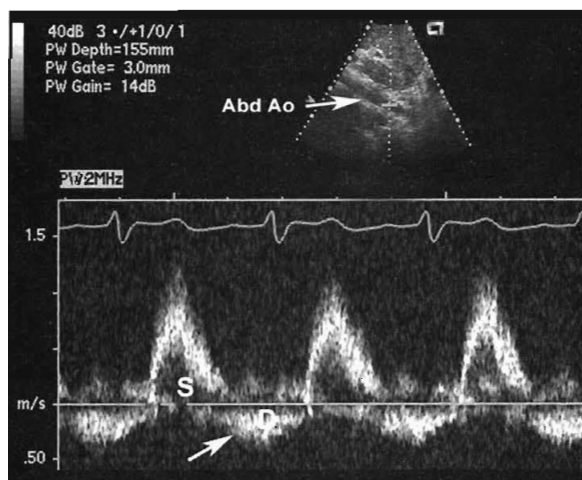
In the same patient as Figure 103-5, pulsed Doppler flow in the proximal abdominal aorta (Ao) shows normal forward flow in systole (S), with abnormal flow in diastole (D) that extends throughout diastole. This finding is highly specific for severe aortic regurgitation and can be helpful in the acute setting.
